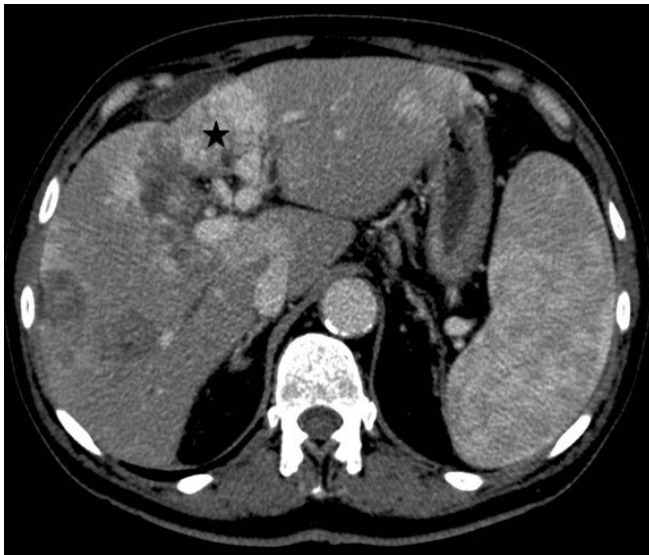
Contrast enhanced CT scan in the arterial phase demonstrates nodular and heterogeneous liver lesions with peripheral hypervascular appearance (black star).
